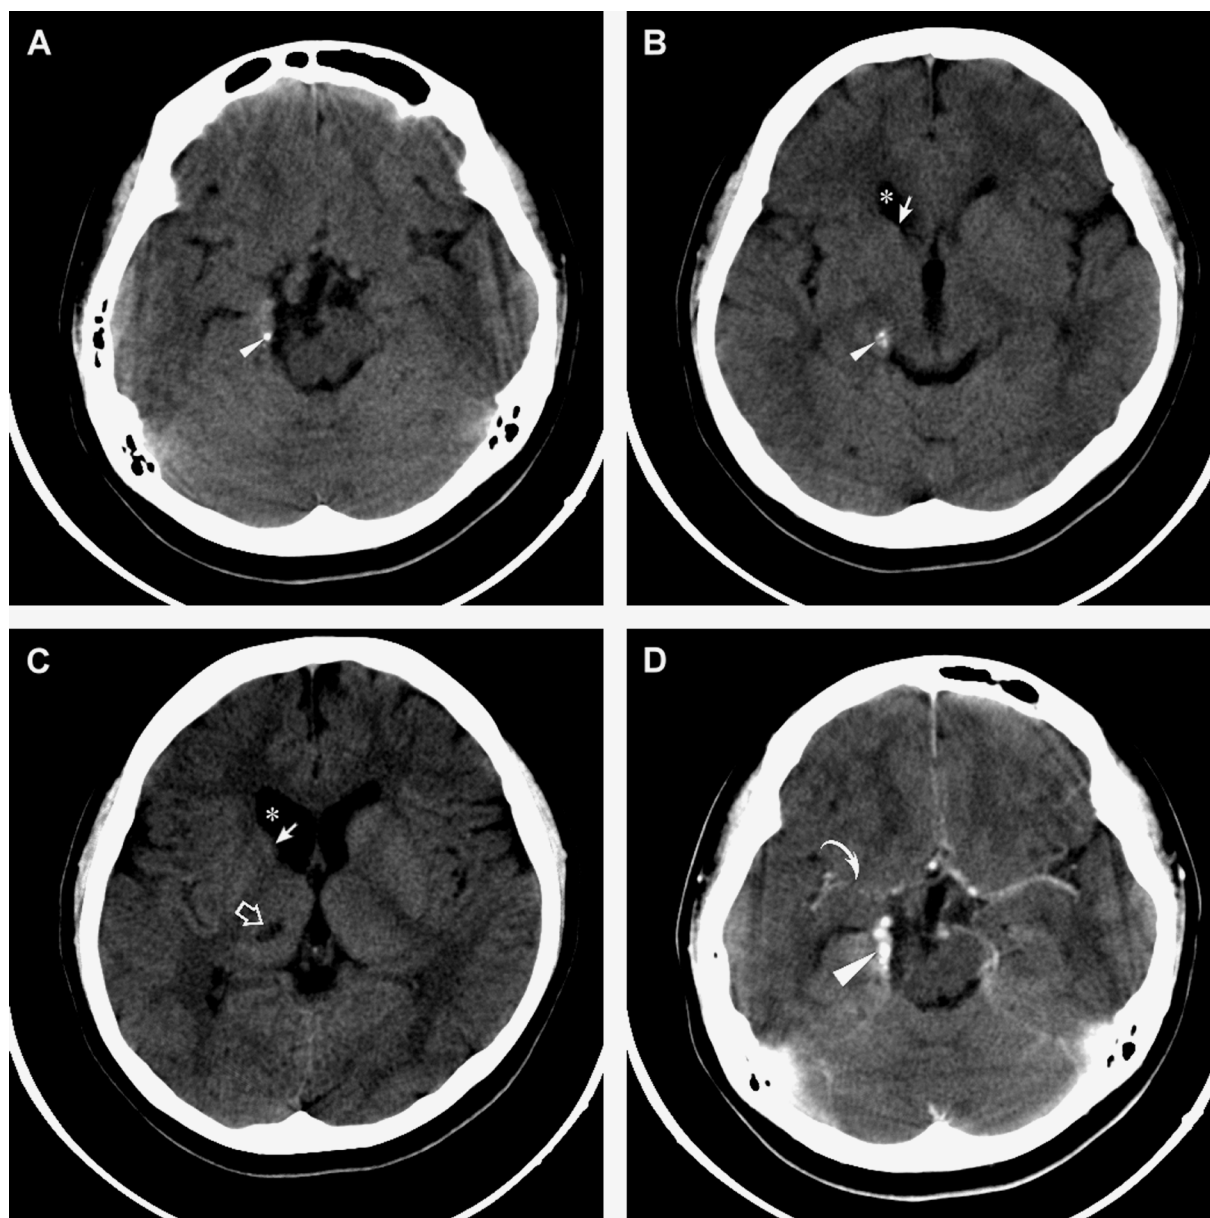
Noncontrast axial computed tomography (CT) images of the brain (A-C) revealed (1) abnormal calcification (small arrowheads) adjacent to the right uncus and in the ambient cistern; (2) lacunar infarct (open arrow) in the right thalamus with presumed Wallerian degeneration of the right cerebral peduncle; (3) asymmetric bilateral heads of caudate nuclei, with an overt atrophic right one (arrows); and (4) asymmetric bilateral frontal horns of the lateral ventricles, with dilation of the right one (*). Contrast-enhanced axial CT images of the brain (D) revealed that the abnormal calcification is along an abnormal vessel (large arrowhead), the middle cerebral arteries are asymmetric, and the right middle cerebral artery (curved arrow) is overtly small calibrated and shows irregular contour.
